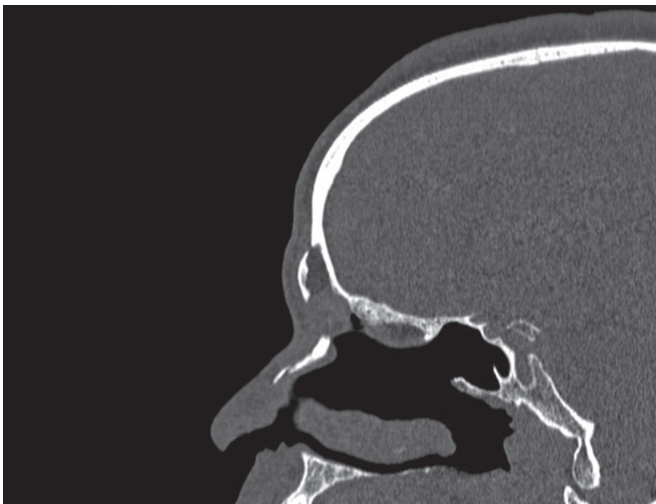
Sagittal CT demonstrating mucocoele.
